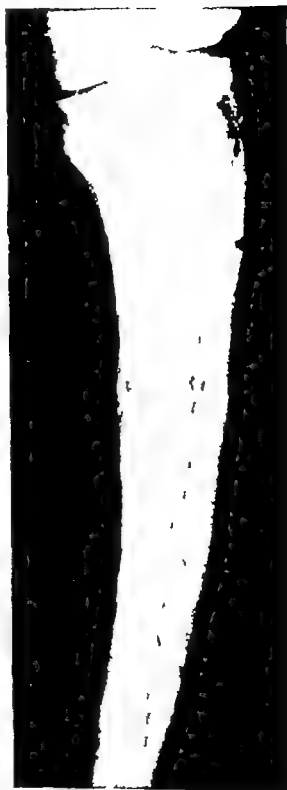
Osteogenic sarcoma on Paget's disease (Paget's sarcoma) The tibial lesion is only one of many which were typical of osteitis deformans. Persistent pain increasing in severity prompted repeated roentgenographic examinations of the tibial area. Two months after this film was made another was thought to confirm the suspicion of osteogenic sarcoma, and a biopsy established the diagnosis.
